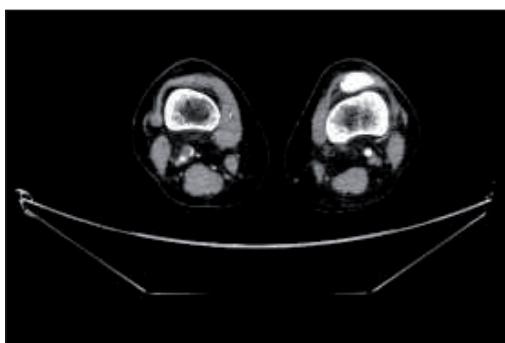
CT-angiography showing dilatation of the popliteal artery.
